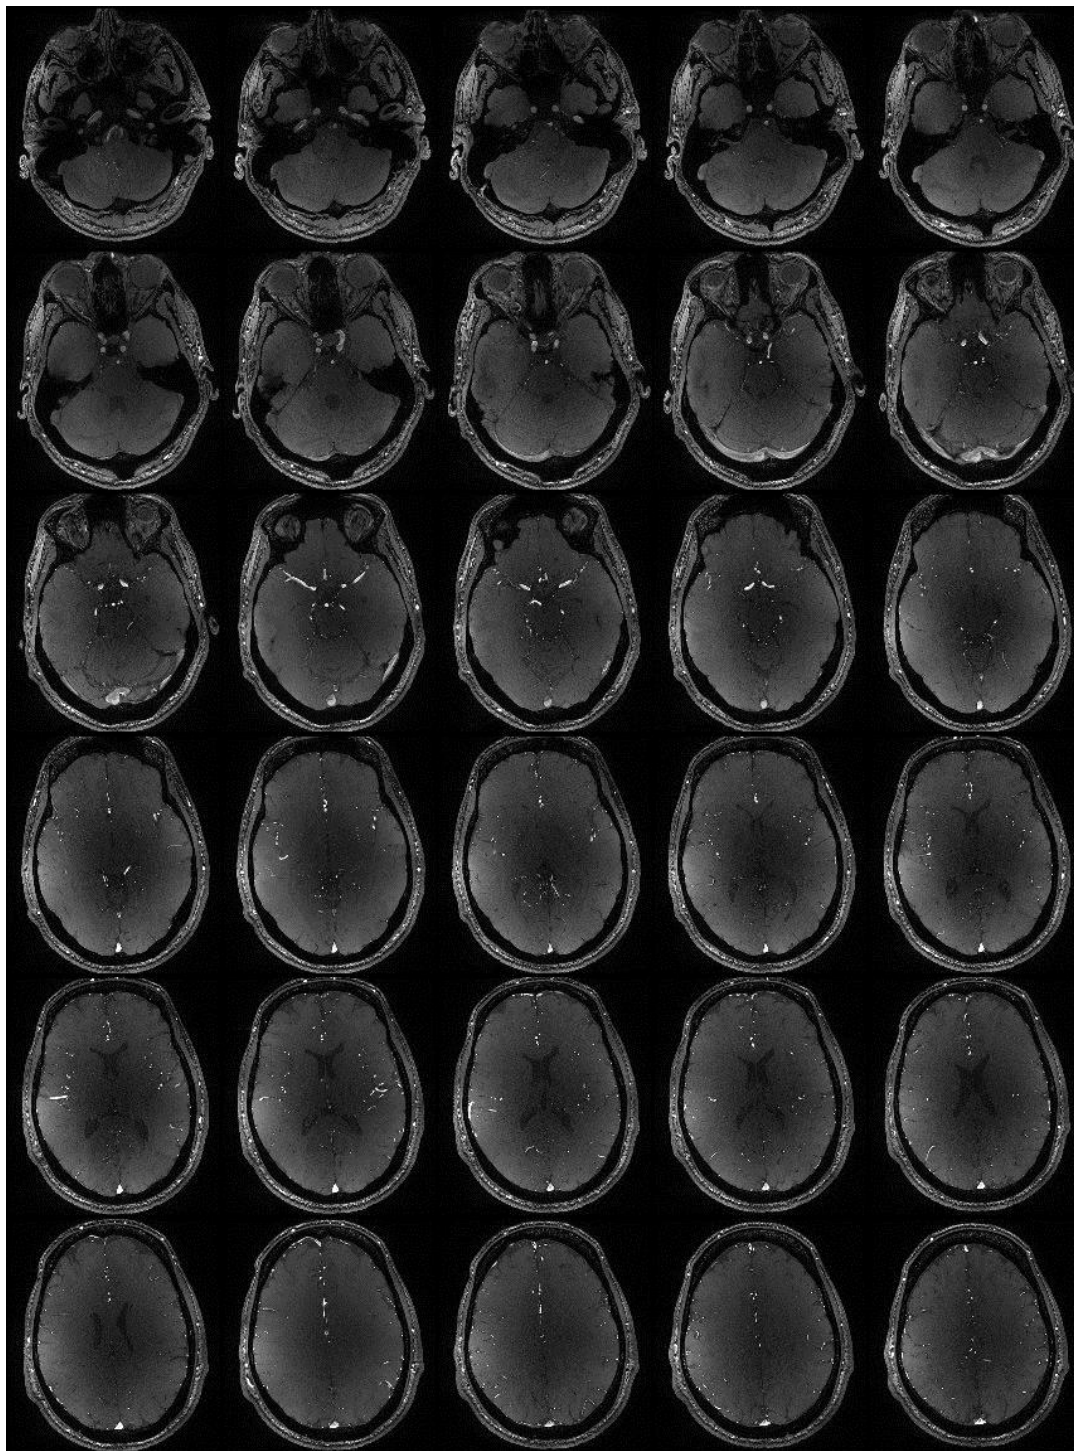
Figure B-1. MRI montage image of normal subject 1
